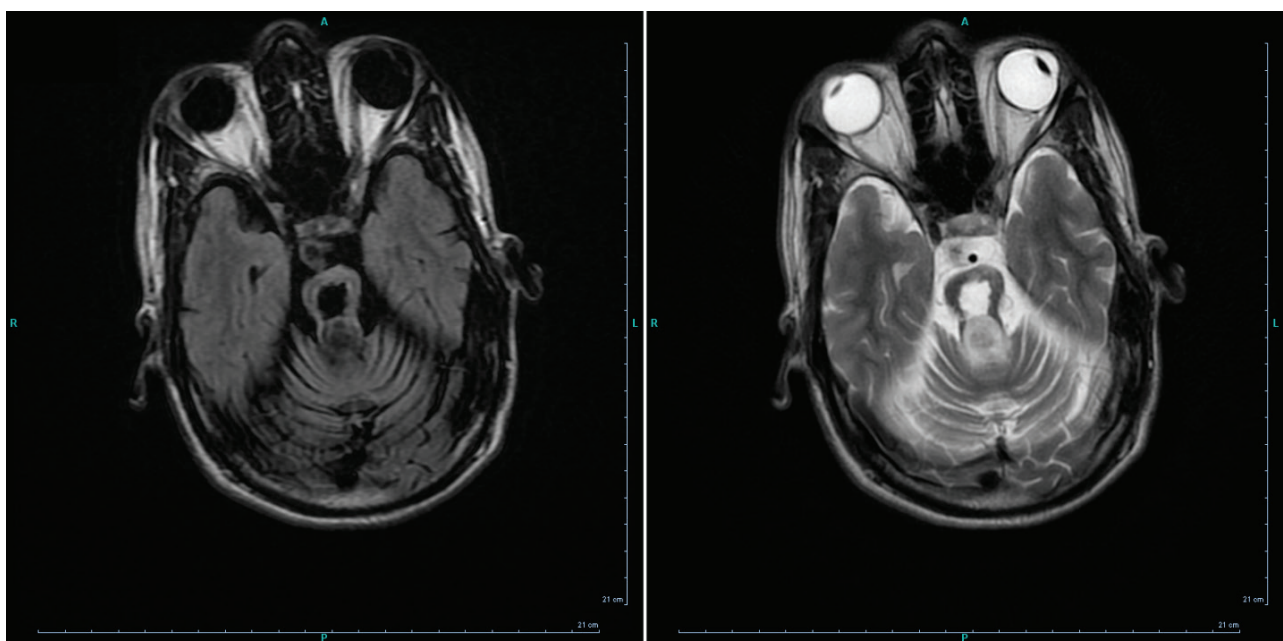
Axial T1- (A) and T2-weighted (B) brain MRI image showing syrinx formation in upper pons and lower midbrain of the patient.
